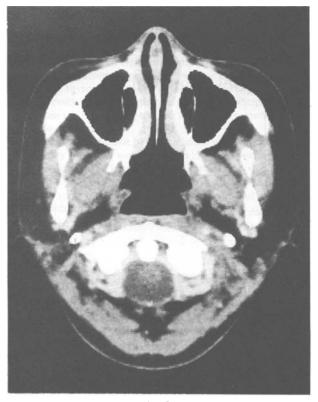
CT scan on 16 March 1989, showing no recurrence of tumour of the nasopharynx.
